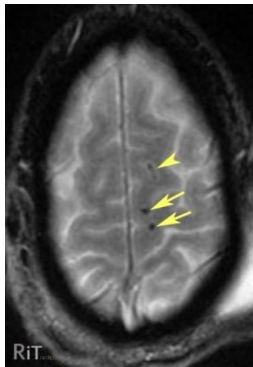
MRI scan indicating axonal lesions
